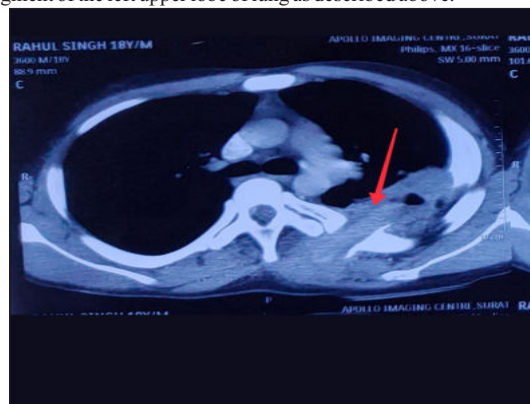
Axial Section Of The CT Thorax With Red Arrow Pointing To The Foreign Body In Left Upper Lung, Adjacent Pleura And Left Para-vertebral Soft Tissues.
